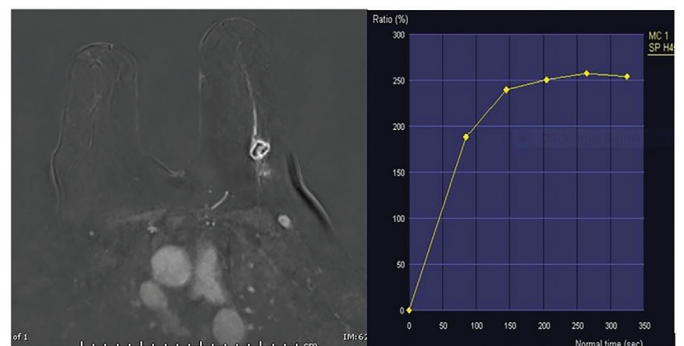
Triple negative breast cancer in 60-year-old women-Subtracted T1-weighted contrast-enhanced image shows oval shape mass with circumscribed margins and rim enhancement. The lesion shows a Type 2 contrast enhancement pattern
